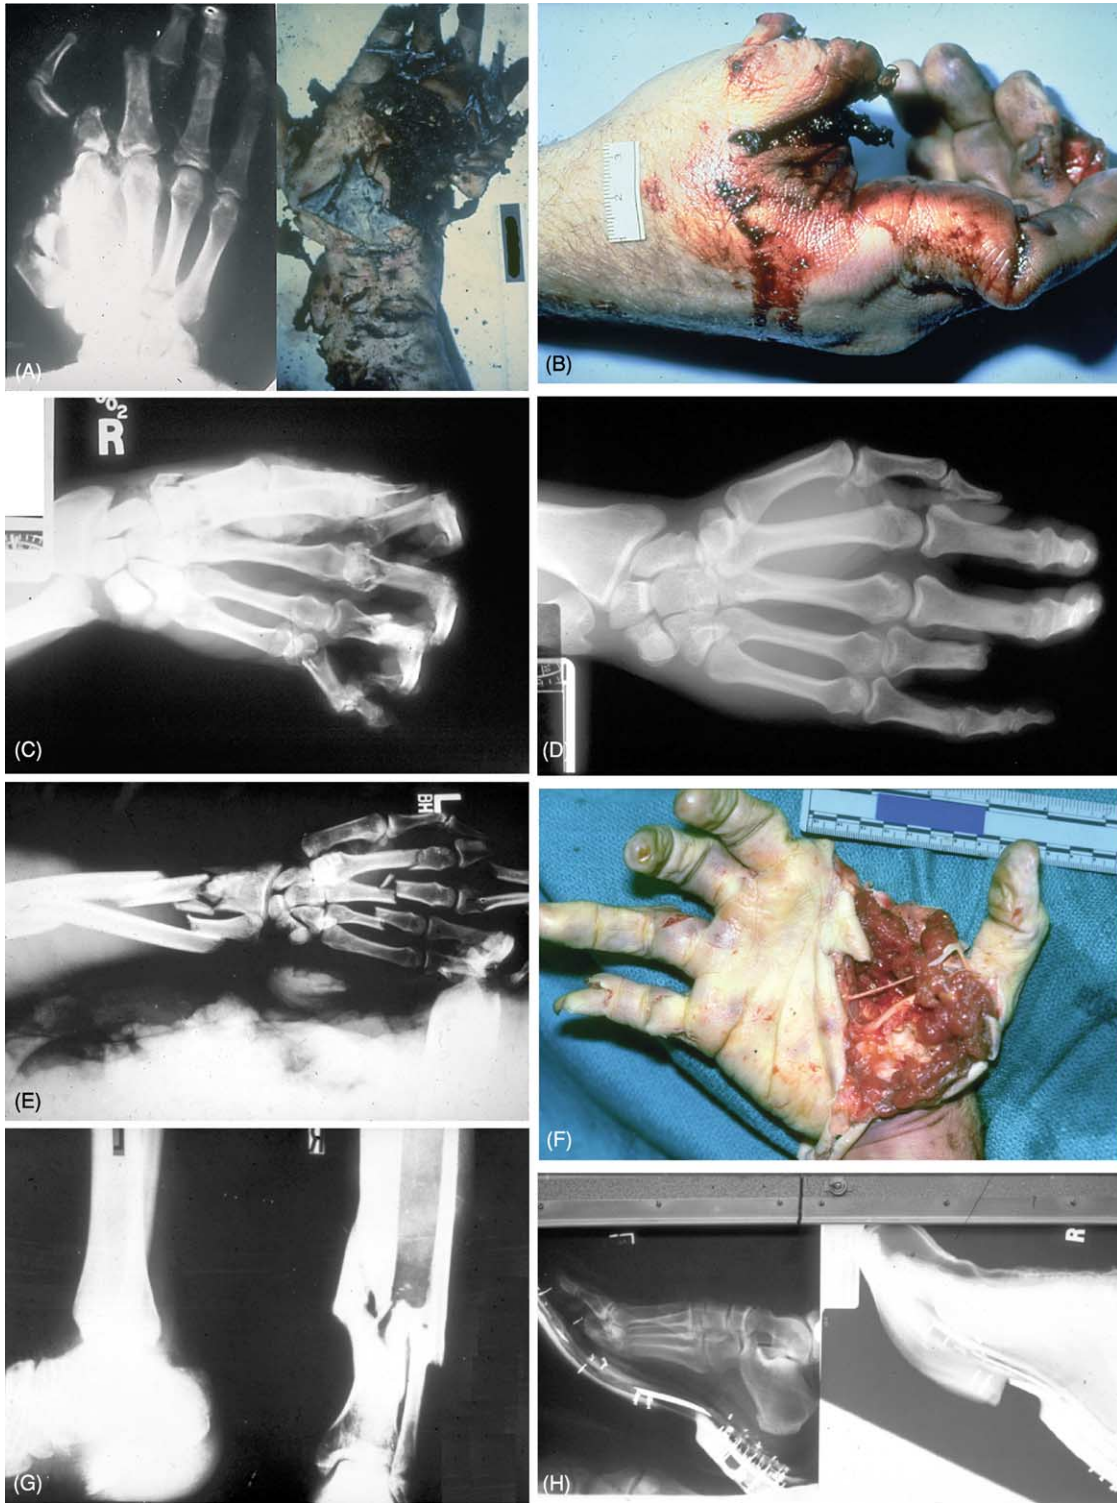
Hand and foot injuries including radiographs – control surface injuries. This series of photographs is of common soft tissue and skeletal injuries encountered on the hands and feet when they are in contact with aircraft controlling surfaces (rudders/pedals for the feet, yoke/control stick for the hands). The fractures are predominantly transverse rather than diagonal and are relatively uniformly spread across the bony structures. The pattern is consistent with the design of the aircraft’s control surfaces. Those forces are also transmitted through the extremity to proximal joints/articulation. The most common soft tissue injuries are those to the soft tissues of the thumb and represent the thumb’s usual apposition to the hand’s other digits. The figures of the feet with boots on show bending of a longitudinal metal plate in the boot and separation of the sole. This finding is indicative of a force transmitted vertically through the foot. The significance of these findings are interpreted as proof of the pilot/aircrew member trying to control the aircraft at impact rather than being incapacitated (unconscious or not at the controls).
